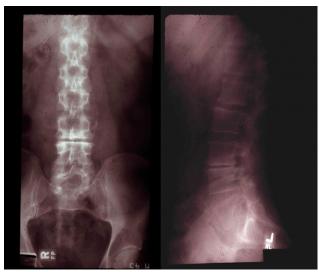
An example of the AP (frontal) and lateral (side view) plain lumbosacral spine X-ray in a patient. The bone is seen clearly as is the narrowed degenerative L3-4 intervertebral disc level. The neural elements cannot be seen.
